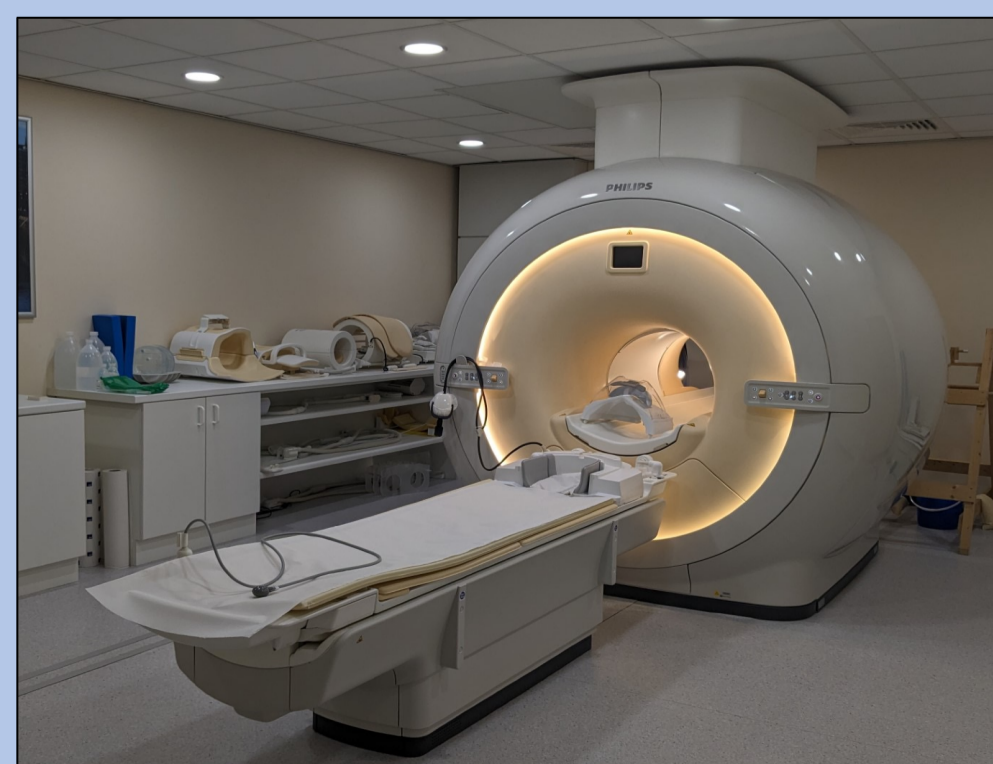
Image of an MRI Scanner at the Newcastle Research Centre
